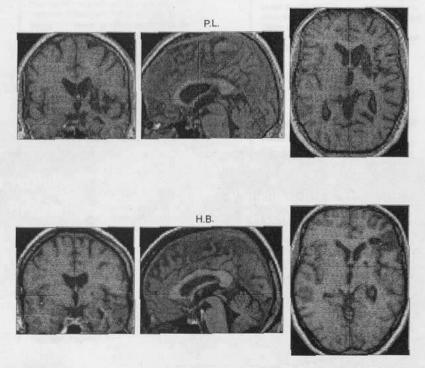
Structural MRI of patient P.L. (top) and patient H.B. (bottom). The figure shows coronal, sagittal and transversal cuts through the lesioned areas of the patient's brain. For P.L., the additional global brain atrophy is visible, too.
